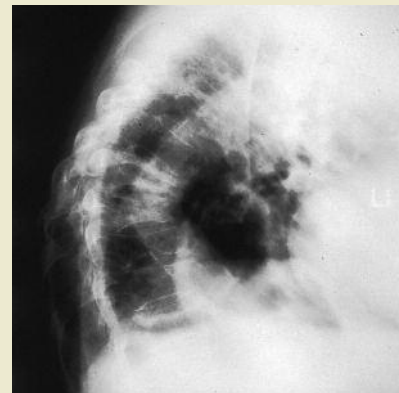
X-ray showing osteoporosis with crush fractures of the mid-thoracic spine.
